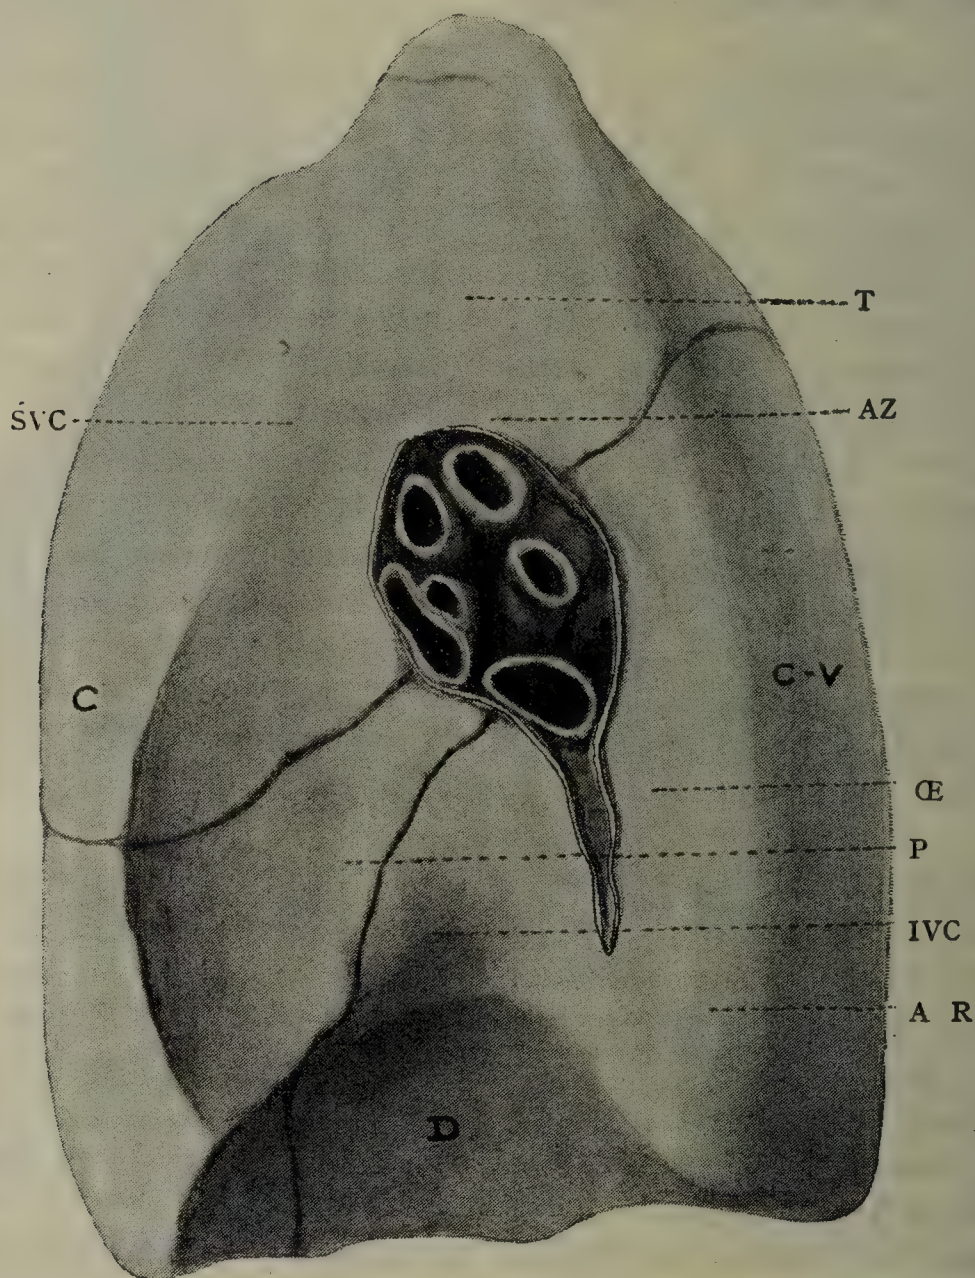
MEDIASTINAL ASPECT OF RIGHT LUNG.
